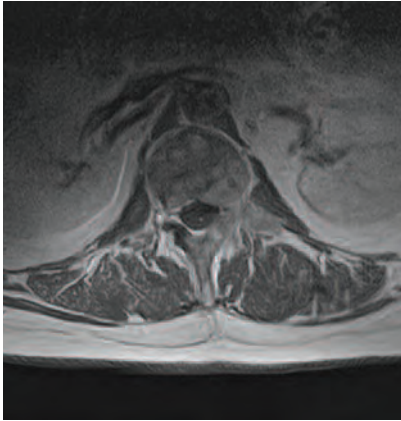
Transverse section of T1-weighted MRI with contrast showing a fractured L1 with multiple metastases.
